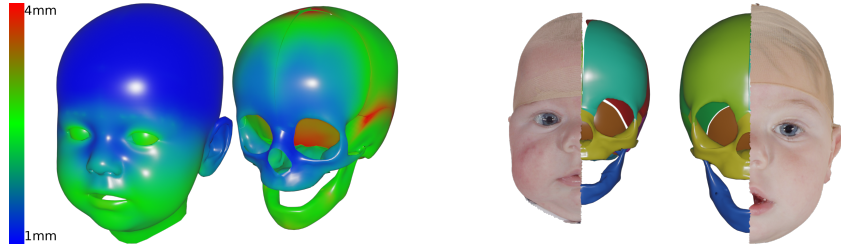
Left highlights the regional accuracy of face and skull inference, averaged over the CT dataset. Right demonstrates skull inference on non-invasive photo scans for the same baby at three and eleven months.
